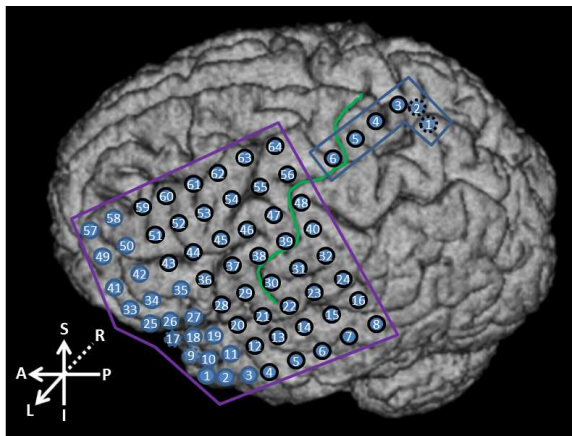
Magnetic resonance image (MRI) of a participant in [149] (© 2013 IEEE) with ECoG electrodes localized using the technique described in [151].
